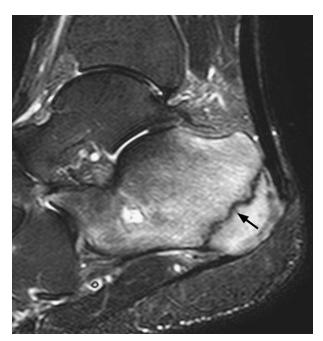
Saggital magnetic resonance imaging of 30-year-old recreational runner with stress fracture of calcaneus. This is a clear fracture line extending across the posterior aspect of the calcaneus with surrounding edema. Radiograph was negative.
